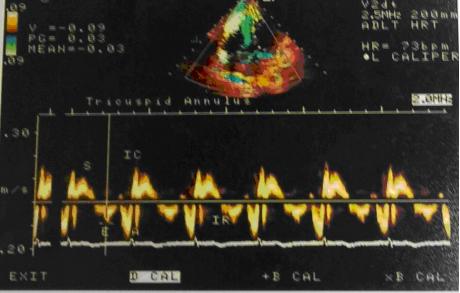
Pulsed wave Doppler tissue imaging (DTI) after treatment shows negative deflect velocity recorded at the tricuspid annulus.
